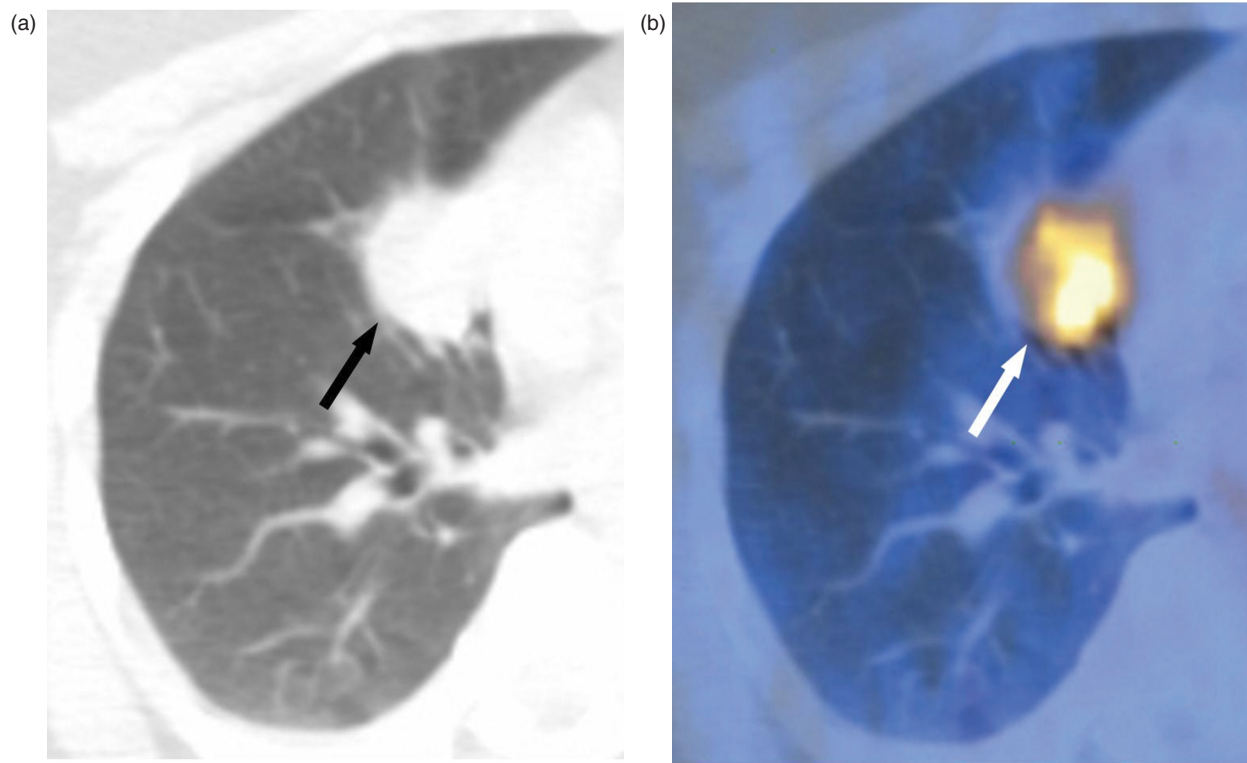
A 44-year-old woman with atypical carcinoid (T1N0M0, IA). (a) Lung window image of a transverse unenhanced CT scan (5-mm section thickness, 40 mAs) obtained at the level of the right inferior pulmonary vein shows a 25-mm-sized nodule (arrow) in the right middle lobe. (b) Integrated PET/CT scan shows high FDG uptake (arrow) within the tumor (SUV_{max}, 7.1).
